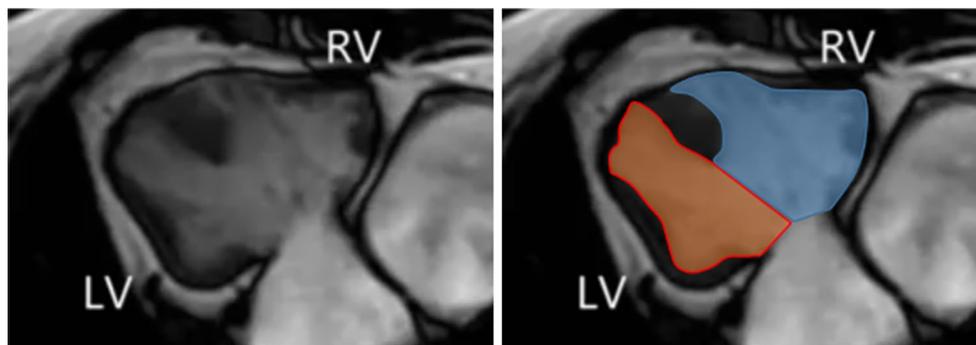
Magnetic resonance imaging used to evaluate end-diastolic volumes (EDV) of the right ventricle (RV) and left ventricle (LV)
